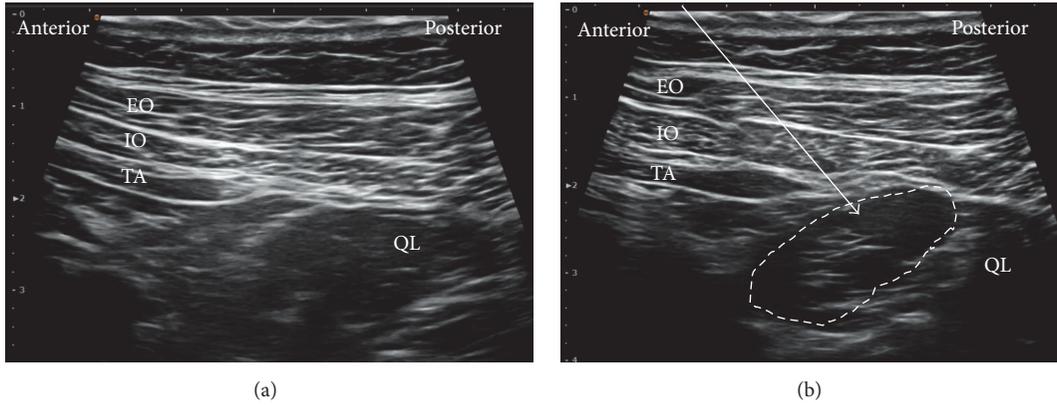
Ultrasound images of lateral QL. (a) Preinjection and (b) postinjection. EO: external oblique muscle, IO: internal oblique muscle, TA: transversus abdominis, QL: quadratus lumborum, white arrow: needle trajectory, and white dotted line: spread of local anesthetic.
